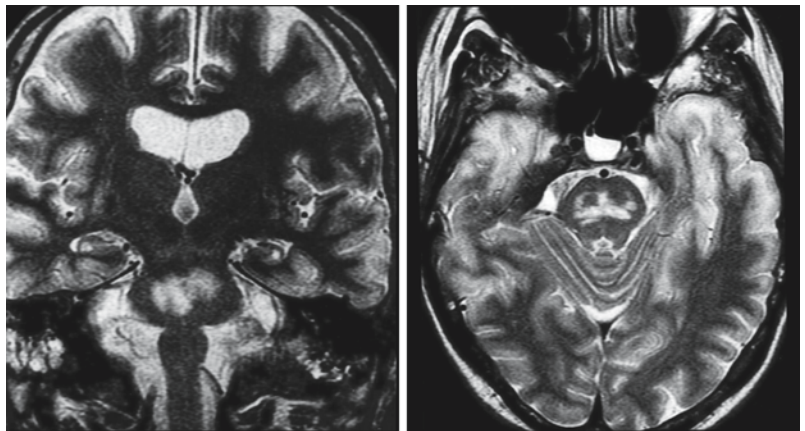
A 44-year-old man with chronic alcohol abuse and hyponatremia. The MRI was obtained in the acute phase of CPM. The characteristic ω -shaped lesion central in the pons in the acute phase is especially well seen on the transverse T₂-weighted image. Courtesy of Dr. B.G. Ziedses des Plantes Jr., Deventer Hospital, Deventer, The Netherlands
